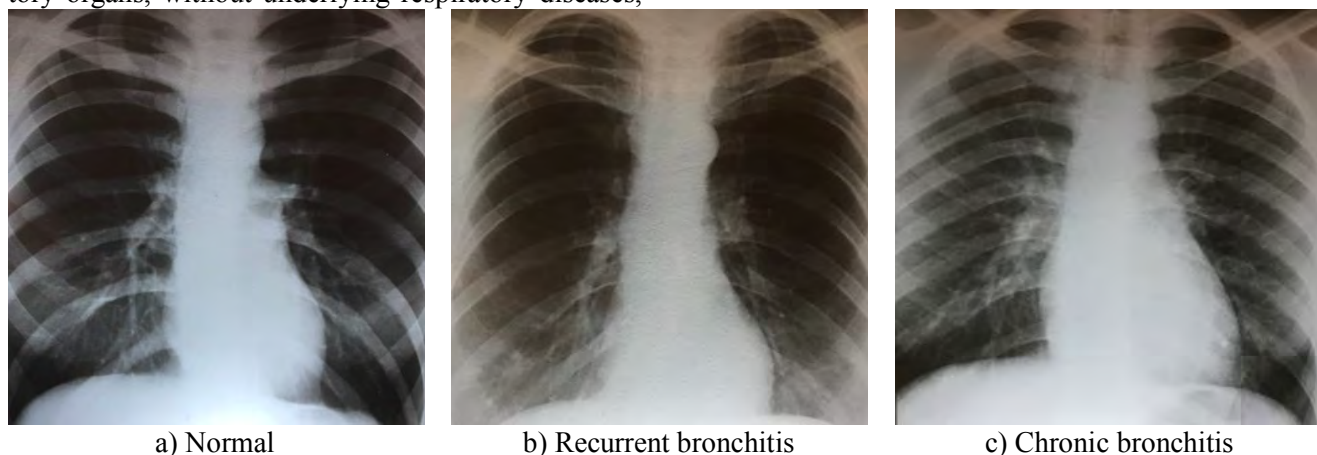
Examples of X-rays
